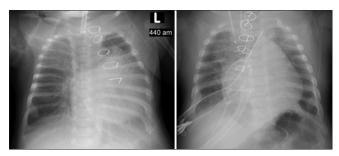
Chest X-ray demonstrating severe left lung collapse before stent placement with consequent resolution following stent placement and Glenn procedure
